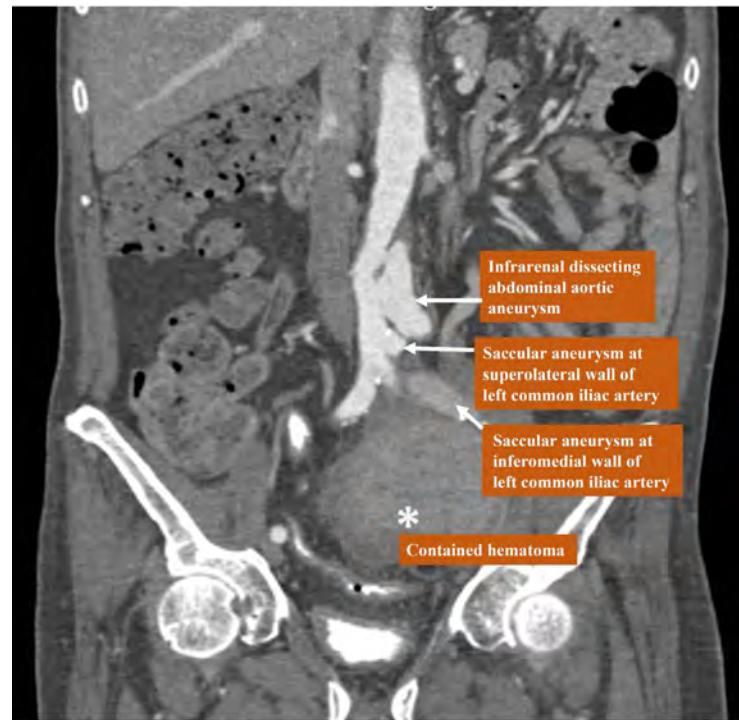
Computed tomography angiography (CTA) of abdomen, coronal view shows presence of two contrast filled lobulated saccular aneurysms seen at left common iliac artery. The smaller aneurysm at superolateral wall of left common iliac artery measures $1.0 \text{ cm} \times 0.8 \text{ cm}$ (AP \times WT) with the defect opening measures 0.8 cm in diameter. Another larger aneurysm arising from inferomedial wall of left common iliac artery measures $5.7 \text{ cm} \times 7.7 \text{ cm} \times 6.4 \text{ cm}$ (AP \times WT \times CC) with the defect opening measures 1.2 cm in diameter. The area marked with * shows contained hematoma from the aneurysms. CTA abdomen also shows infrarenal dissecting abdominal aortic aneurysm (AAA) measures 3.2 cm in its widest diameter. The true and false lumens measure 1.6 cm in diameter respectively.
